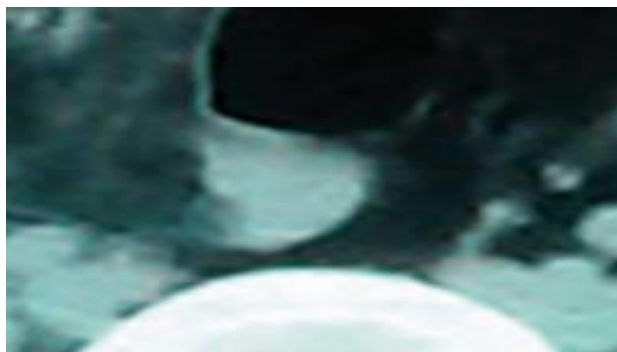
CT images showing greater omental torsion (red arrow) following inguinal hernia.⁴³
